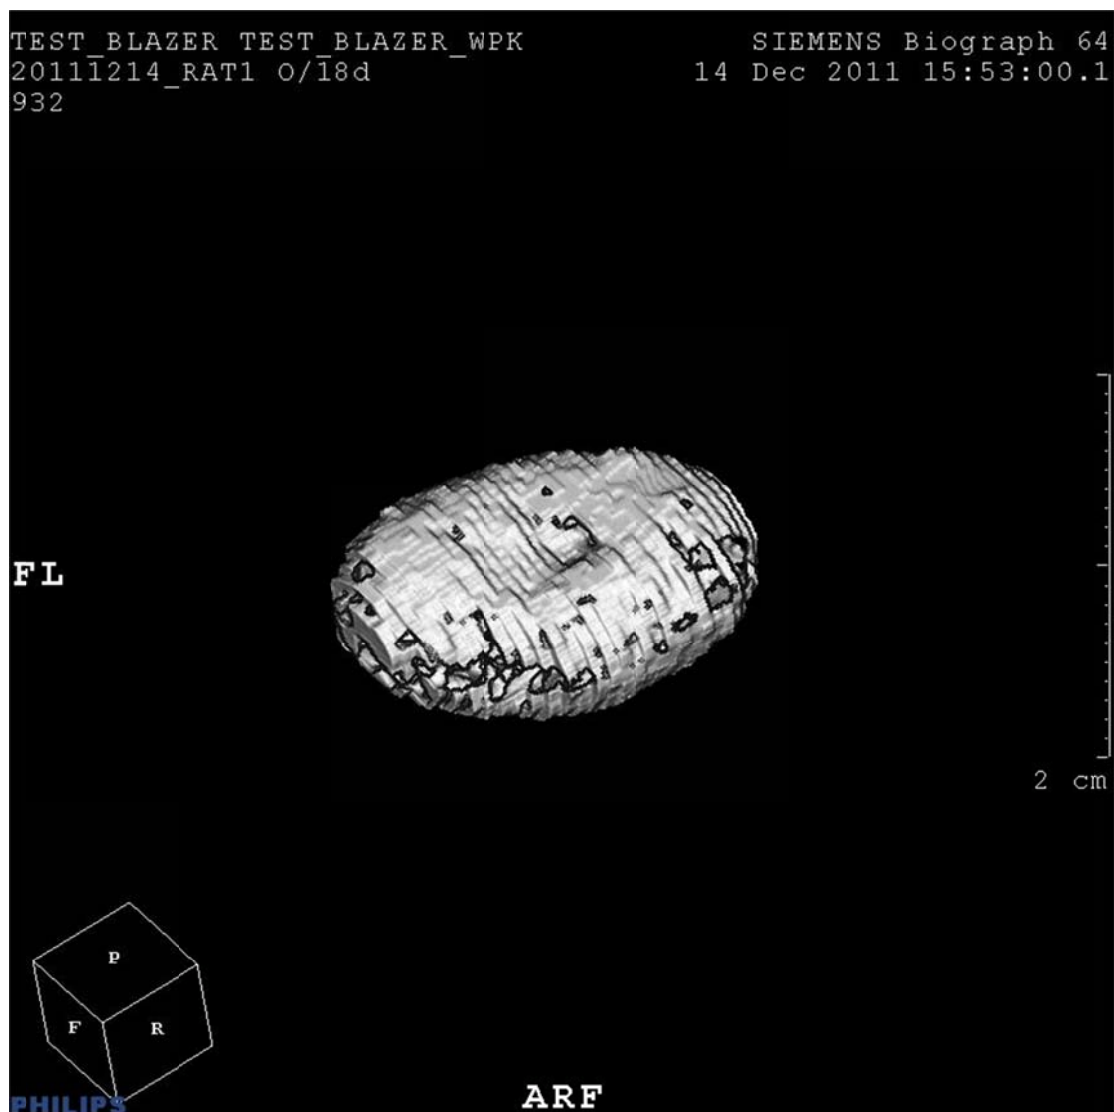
18 Day Pioglitazone 3-D Cystic Normal Image generated from Philips program using CT value ranges
